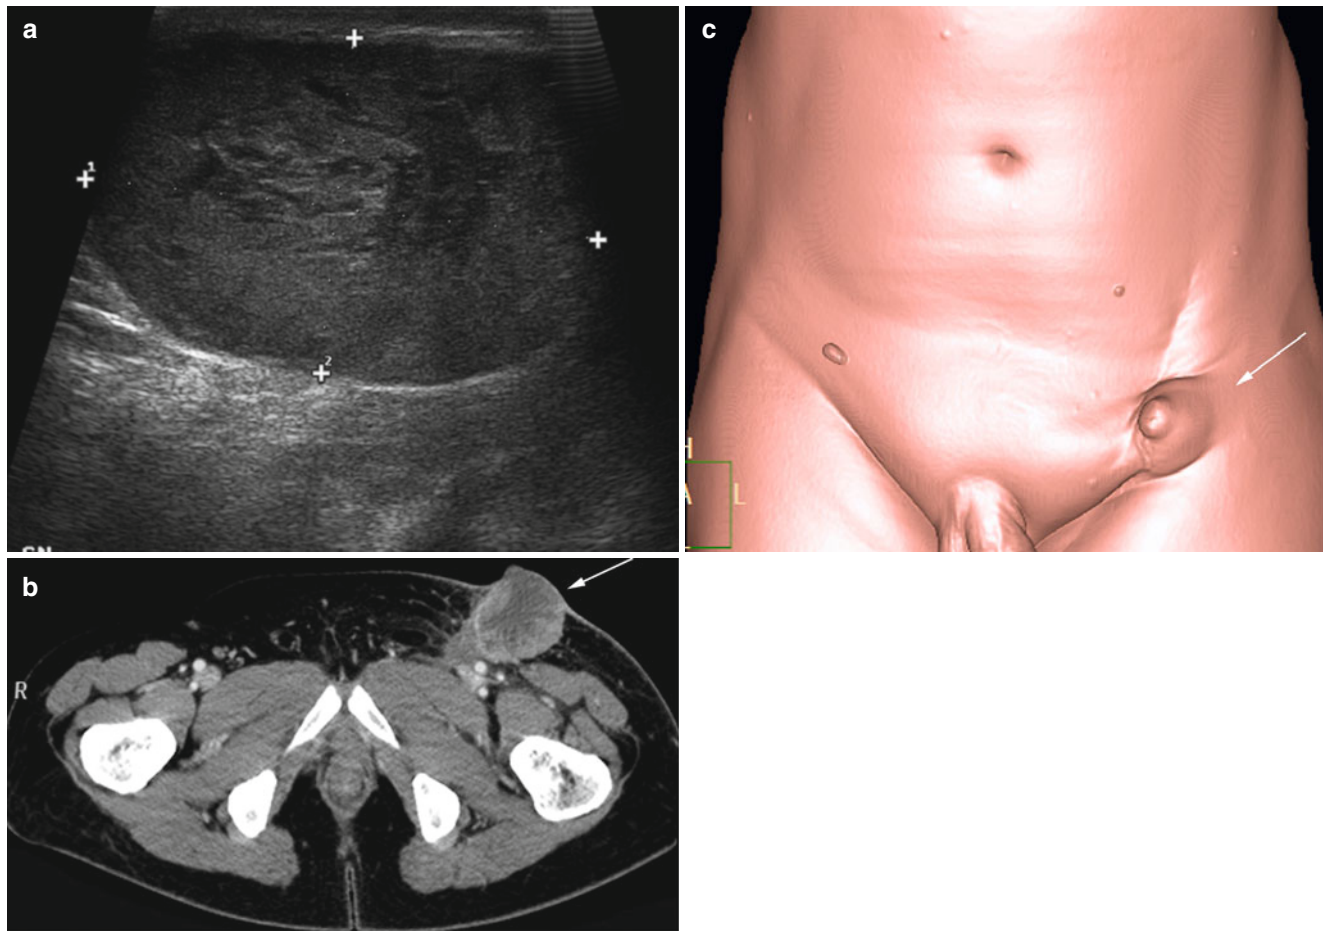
Post-surgical recurrence. A large (56×36 mm) lymph-node mass is seen 8 months after inguinal radical lymphadenectomy (a calipers). The contrast-enhanced axial computed tomography image
